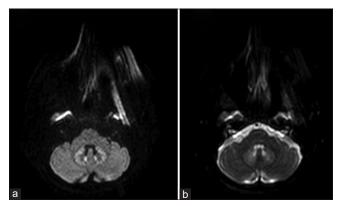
Hyperintensity on bilateral dentate nuclei on diffusion-weighted imaging (DWI) (a), with no corresponding restriction on ADC maps (b)
